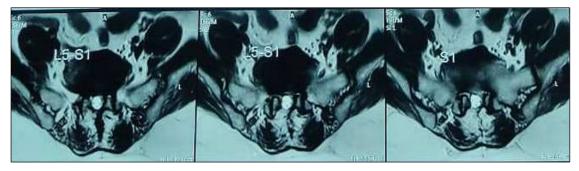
T2 weighted MRI film of L-S spine
